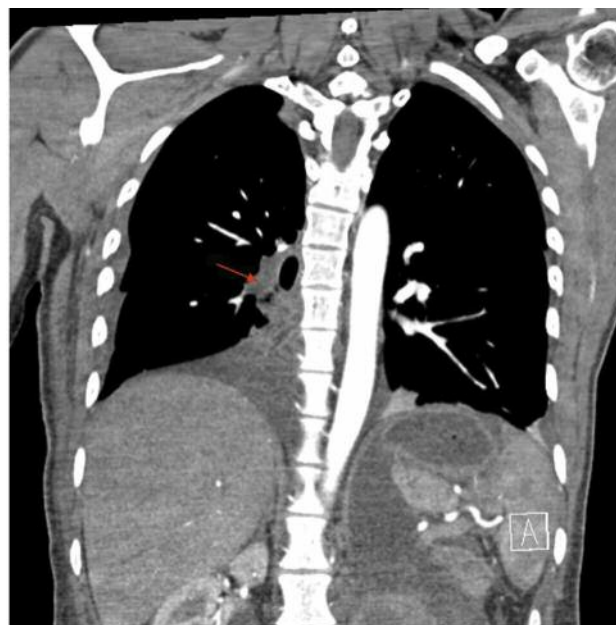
Contrast enhanced chest computed tomography (CT) with defect in contrast filling in the right pulmonary artery (red arrow) compatible with pulmonary embolism.
